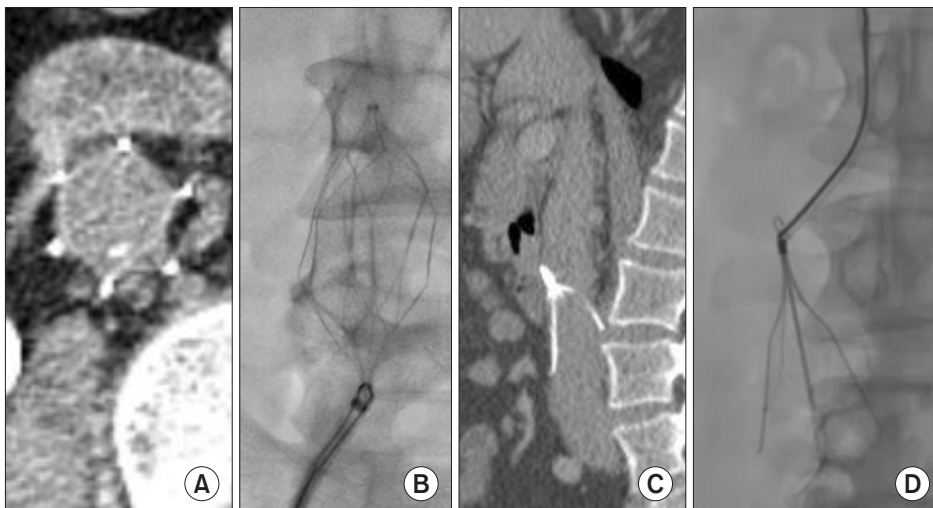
(A) Axial computed tomography (CT) image shows grade 2 perforation. (B) Inferior vena cava (IVC) filter shape changes due to adhesion and external compression. (C) Sagittal CT image shows embedding to the IVC anterior wall. (D) Catheter-steered snare wire use.
